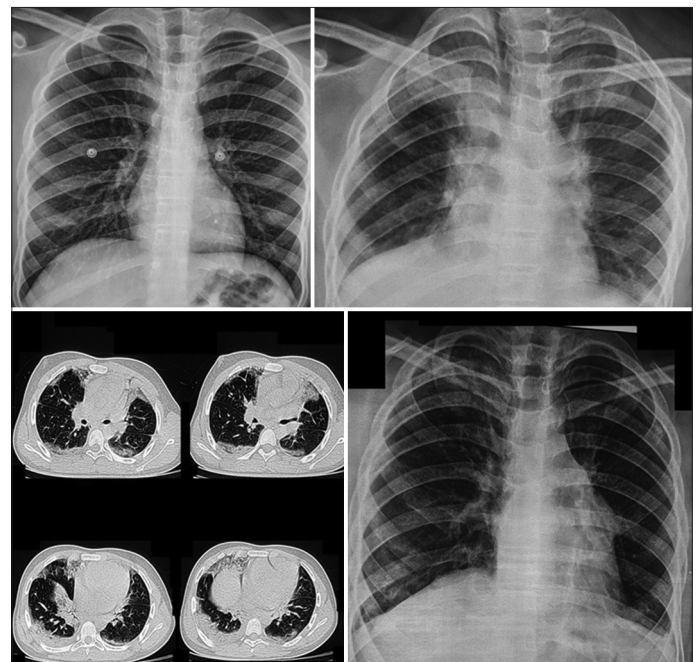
Chest X-rays and high-resolution computed tomography of chest, all of which belong to patient 2. Left upper chest X-ray, taken on admission, is normal. Right upper chest X-ray shows fibrosis, taken on day 7 following admission. Corresponding high-resolution computed tomography of chest taken on the same day. Right lower X-ray showed no progression of fibrosis taken after 6 weeks
